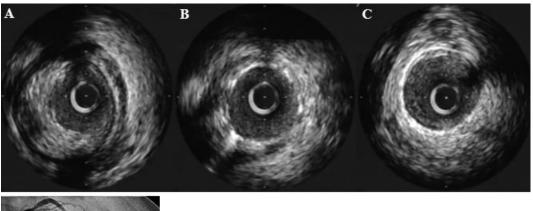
Coronary angiogram (lower) and intravascular ultrasound images (A-C) after stent implantation
